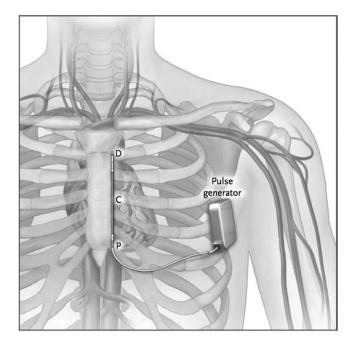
Subcutaneous implantable cardioverter-defibrillator (S-ICD) configuration. The pulse generator is shown near the 5th intercostal space at the mid-axillary line, with the proximal electrode (P), distal electrode (D), and 8-cm parasternal coil electrode (C). From Bardy et al.¹⁷
